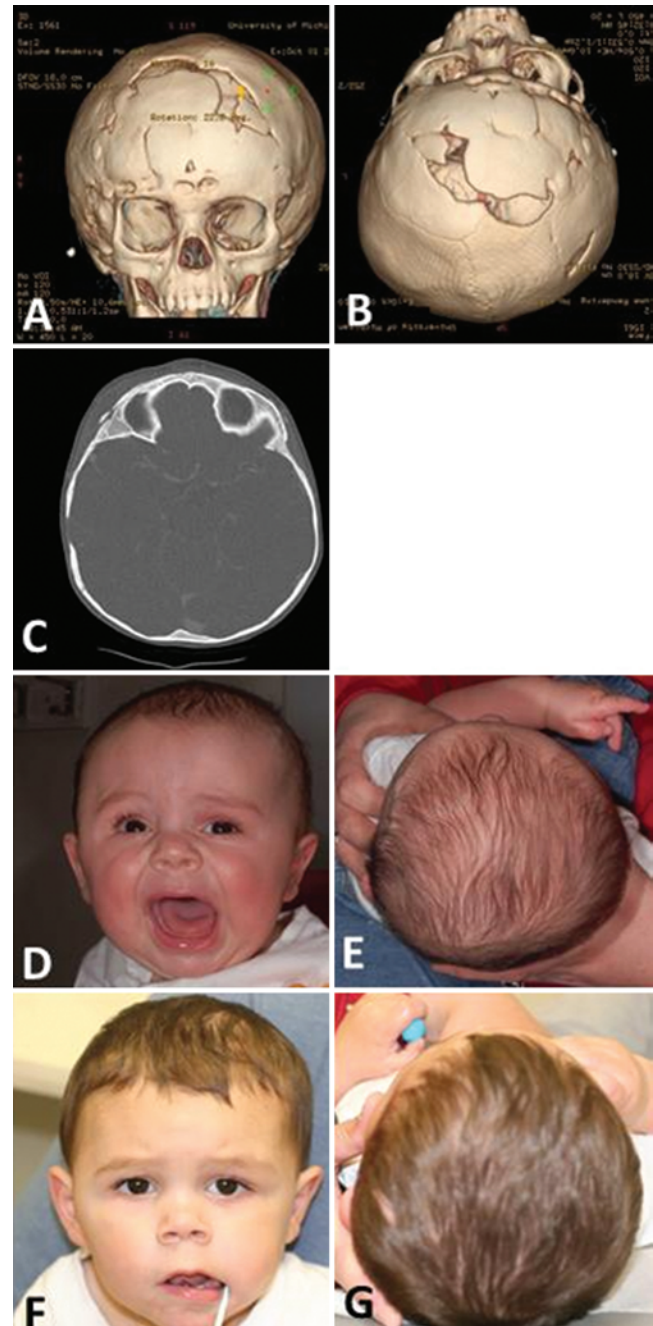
Tomographic and photographic appearance of the cranial vault and face after unicoronal synostosis repair with the hypercorrection technique. A and B: Three-dimensional CT scans. C: Axial CT scan. D and E: The patient's preoperative clinical appearance. F and G: The patient's postoperative appearance.
